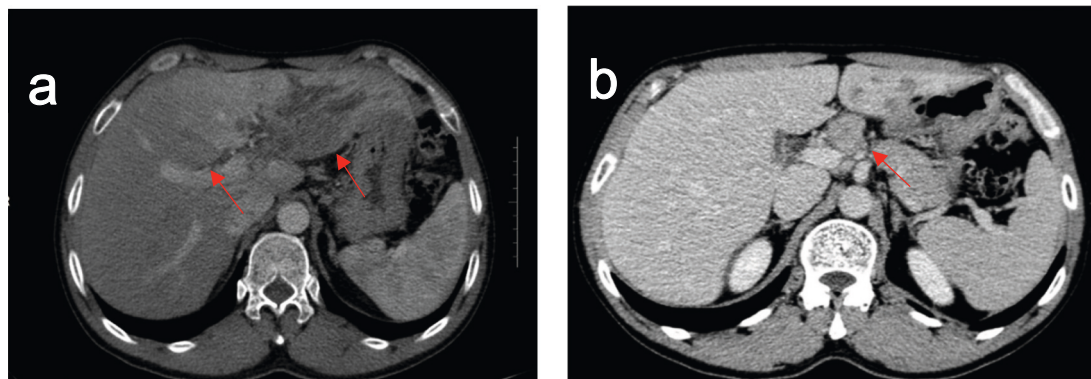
A CT scan of the portal vein, inferior vena cava, and hepatic artery was performed, revealing the presence of multiple tumors in the left lobe of the liver. Images were obtained to document dilated intrahepatic bile ducts (a) and enlarged lymph nodes in the liver region (b).
